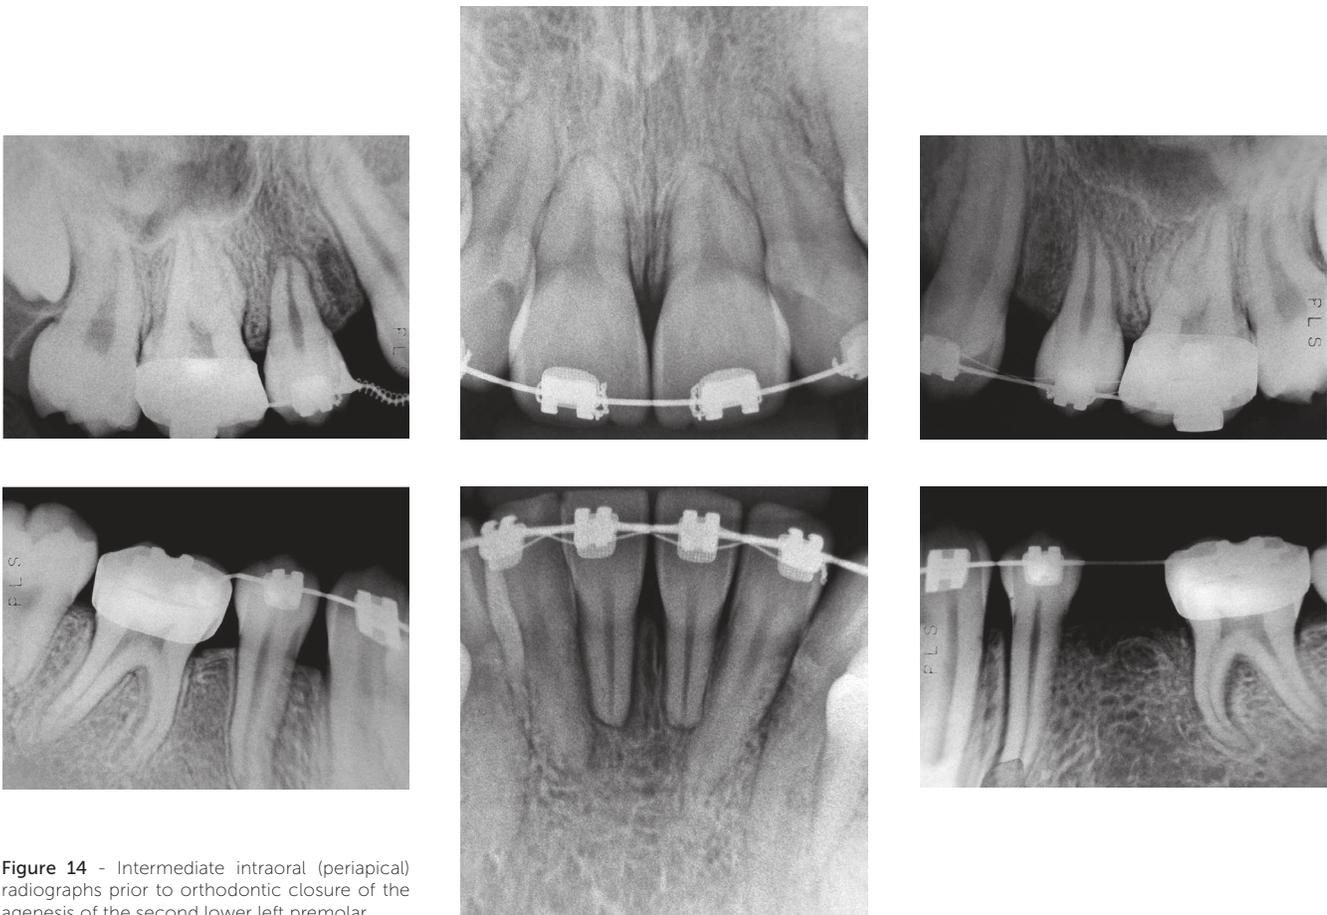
Intermediate intraoral (periapical) radiographs prior to orthodontic closure of the agenesis of the second lower left premolar.
